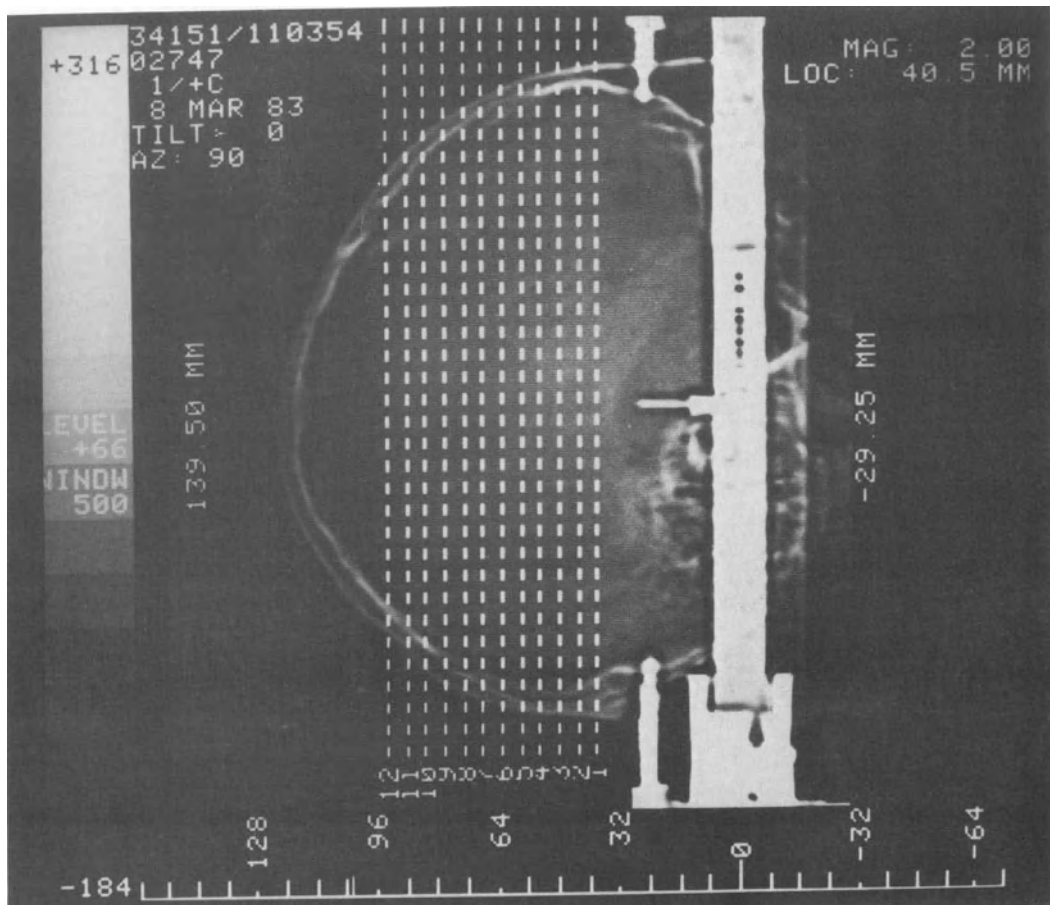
CT stereotactic surgery. By means of an electronic sagittal radiograph, the levels of the CT images are selected. The zero point of the ring coincides with the zero point of the CT system; the scan planes must be parallel to the ring plane.
